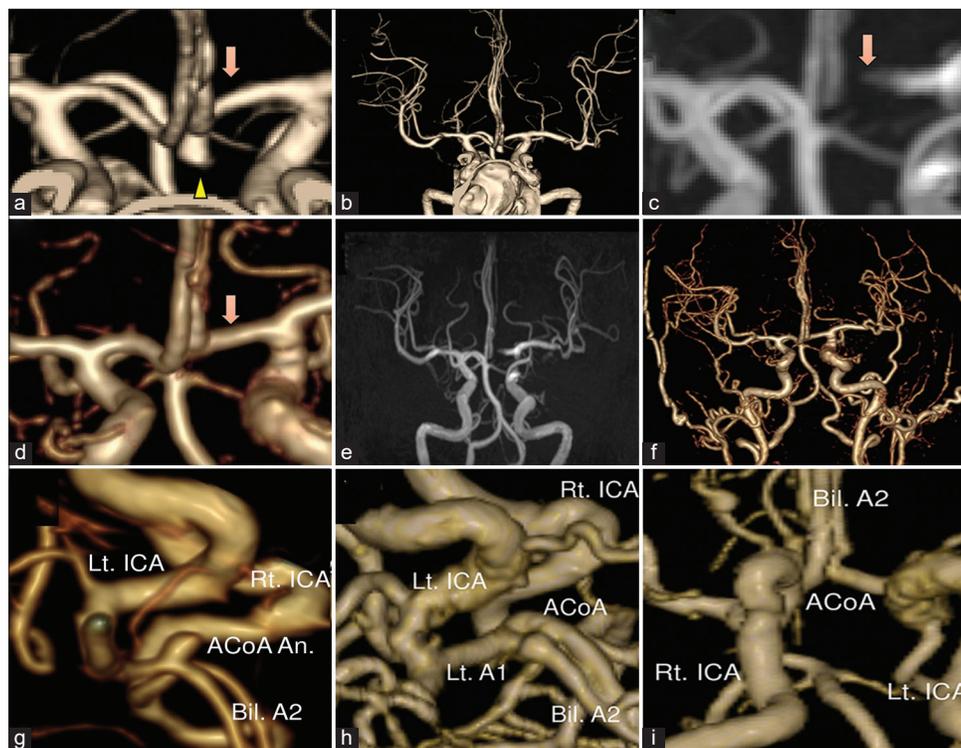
The preoperative computed tomography angiography (CTA) revealed the 4.0 mm aneurysm at the anterior communicating artery (ACoA) (arrowhead, a) and the A1 portion of the anterior cerebral artery (arrow, a) with a wide description range from the main trunk to the peripheral parts (b). On the 5 postoperative day, 3.0T time of flight magnetic resonance angiography (TOF-MRA) did not describe the left A1 (arrow, c), but 3.0T ultrashort echo time MRA (UTE-MRA) described it (arrow, d). Both sequences described the cerebral arteries from the main trunk to the peripheral parts with a wide description range, which enabled the assessment of cerebral vasospasm (e and f). (g) is an operative image reconstructed using the preoperative CTA. (h) is that made by postoperative 3.0T UTE-MRA. (i) is a view from the bottom reconstructed using the postoperative 3.0T UTE-MRA, and it revealed the arteries in the vicinity of the clip, the bilateral A1, A2 portions, and the ACoA, in detail. ACoA: anterior communicating artery, Bil: bilateral, ICA: internal carotid artery.
